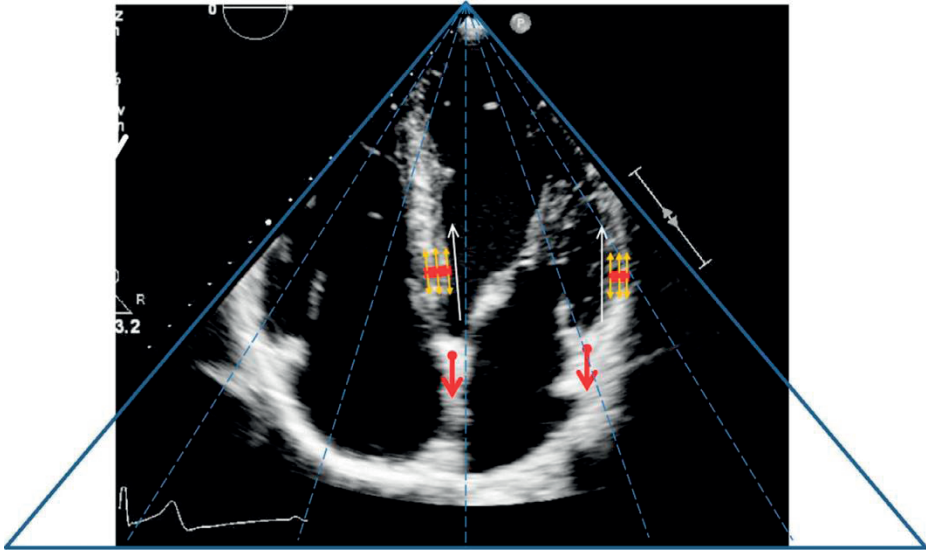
Tissue motion as visible in the left ventricular walls after the atrial contraction, in the apical four-chamber view. Atrial contraction pulls on the mitral annulus (red arrows); this induces a local stretch (small yellow arrows) which propagates along the walls (white arrows) in the form of a tissue Doppler imaging pattern (red line). Note that the direction of the ultrasound in the apical view (blue lines) is in line with both the stretch and the direction of propagation.
